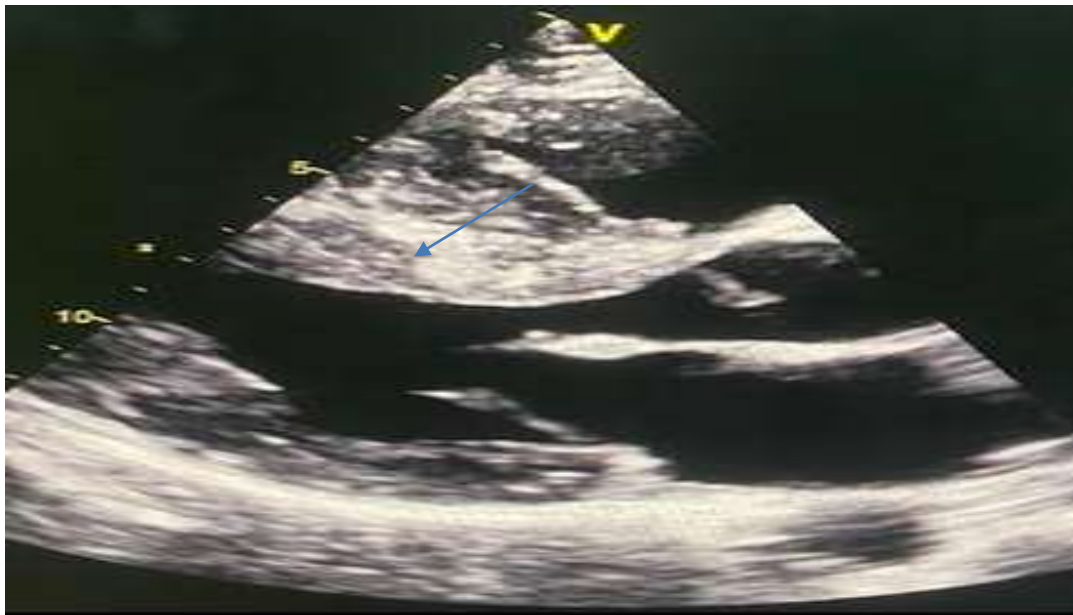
Parasternal long axis section showing septal hypertrophy
